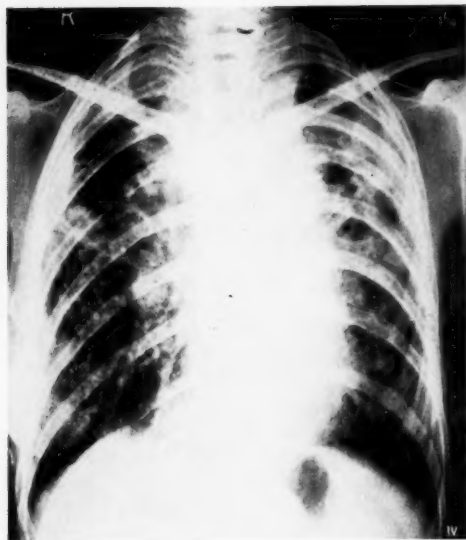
Radiograph in August 1956, showing increased shadowing in the right upper zone and a large left apical cavity.
